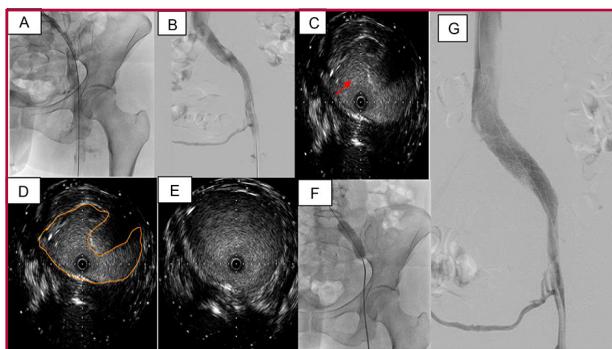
A: Angiographic image after thrombolytic infusion with a Zelante DVT™ catheter using the Power Pulse system. B: Angiographic image after active thromboaspiration using the AngioJet™ isovolumetric system during 130 seconds, with evident improvement in vascular flow and significant decrease in the thrombotic burden, without evidence of imprinting or filling defect in the ostium of the left iliac vein. C: intravascular ultrasound which evidences the zone of decrease in the caliber of the light with the Red Arrow D: intravascular ultrasound which evidences the zone of decrease in the caliber of the light where is indicated the contour of the vessel. E: Intravascular ultrasound showing the normal diameter of the vein without compression. F: Angiographic image showing the 15 x 40 mm balloon insufflated in the iliac vein; the red arrow indicates the waist corresponding to the area of compression documented by intravascular ultrasound. G: Angiographic image showing the final result after implanting a 20 x 100 mm Abre™ venous self-expandable stent.
